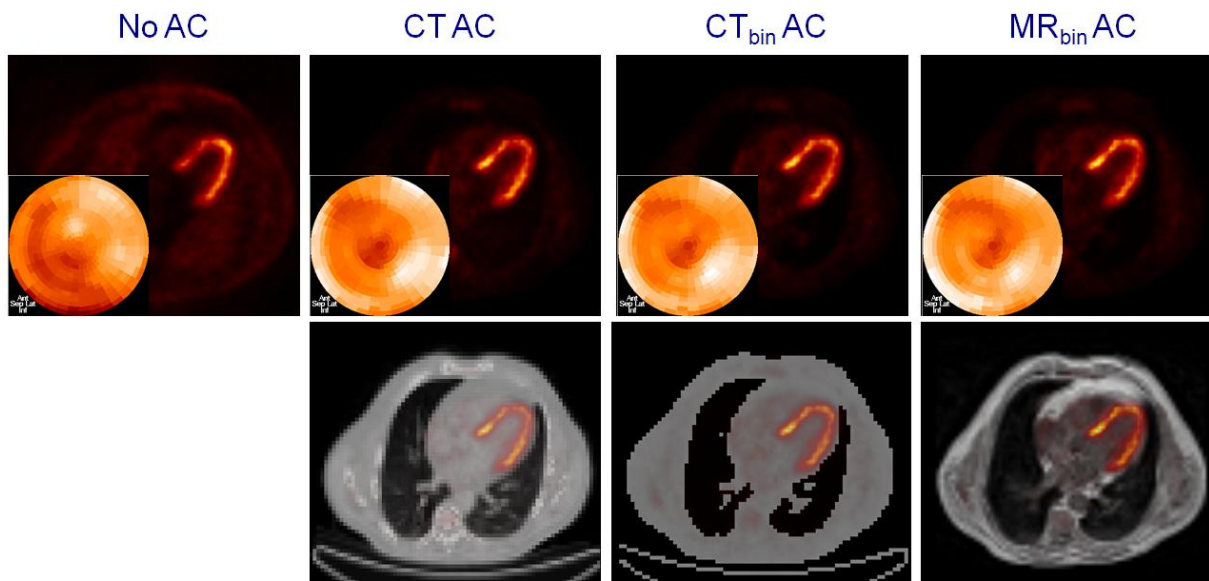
Cardiac transaxial slice and polar map showing the myocardial ^{18}F -FDG uptake (top) observed using the attenuation maps showed in the bottom row. From left to right: data without attenuation correction, with standard CT-based attenuation correction, with binary CT-based attenuation correction, and with binary MRI-based attenuation correction.
